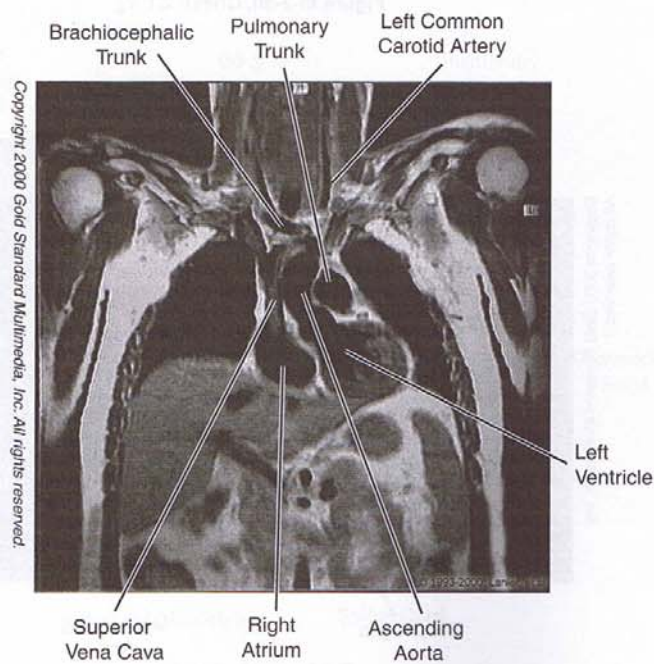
Chest: MRI, Coronal
